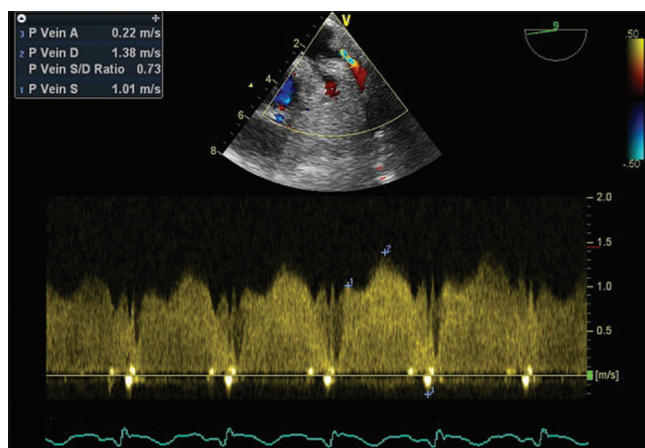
Spectral Doppler of the left upper pulmonary vein showing elevated velocities
